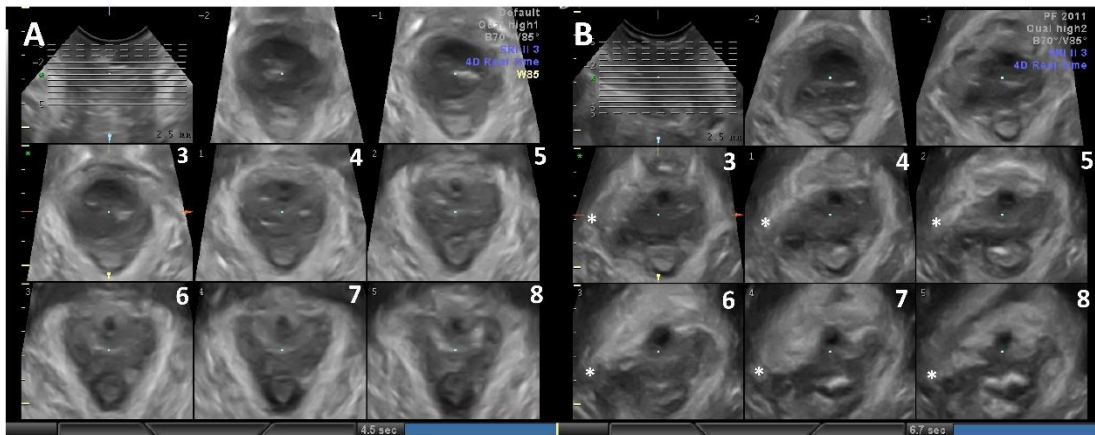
Tomographic ultrasound imaging (TUI), at 2.5 mm interslice interval showing intact levators (A) and a right sided levator avulsion, marked with * (B), yielding an LAD score of 6.
